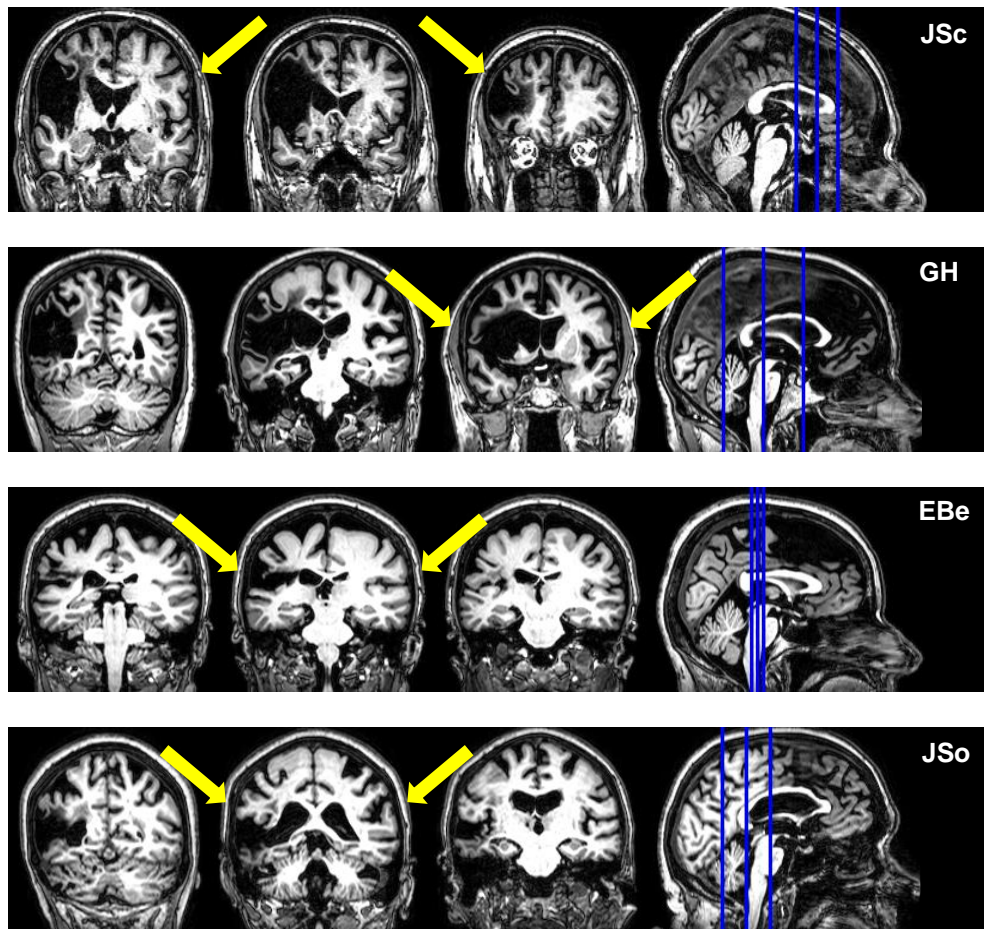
MRI images of participants' lesions, with arrows showing the location of tDCS stimulation sites.
